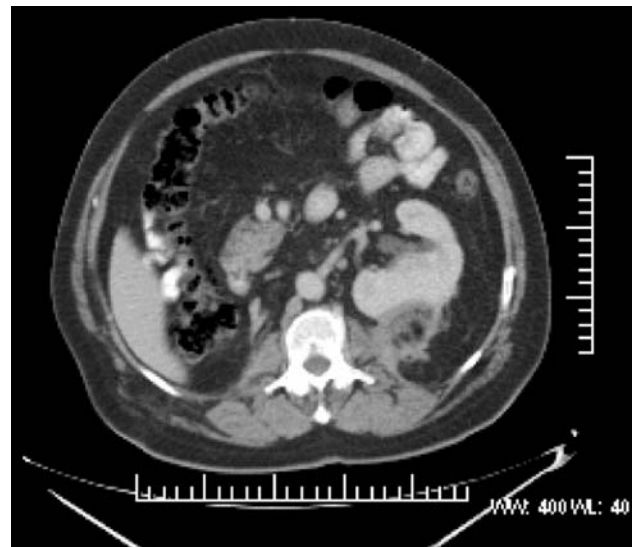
In postoperative second year with contrast CT: small hematoma at lower portion of left kidney
